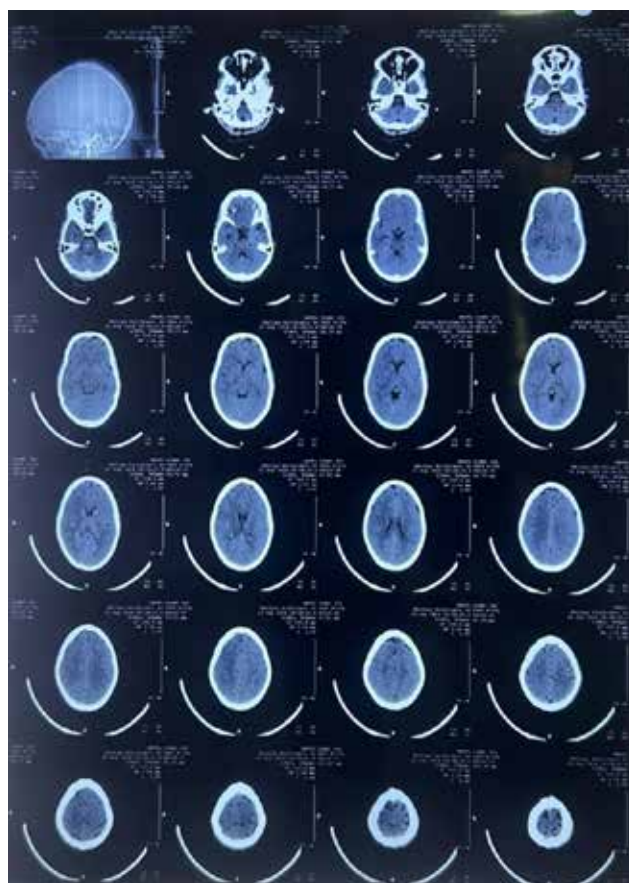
Non-contrast CT scan of the head showed no abnormality.
